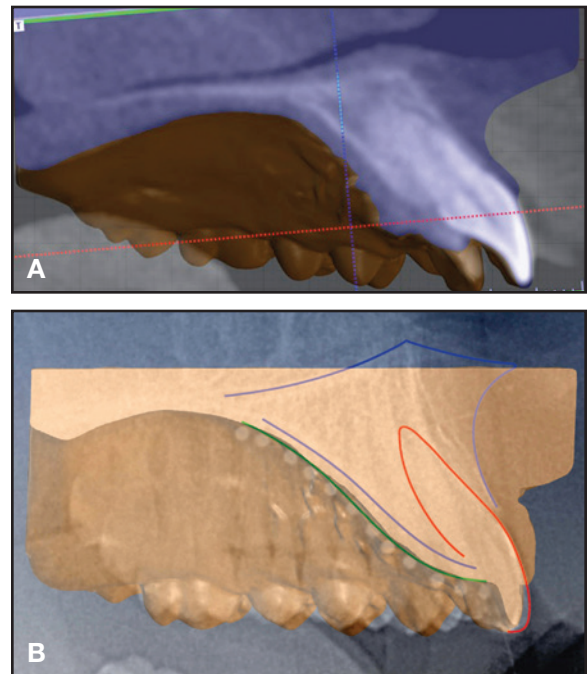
Superimposition of digital model on CBCT (A) and lateral cephalogram (B).
